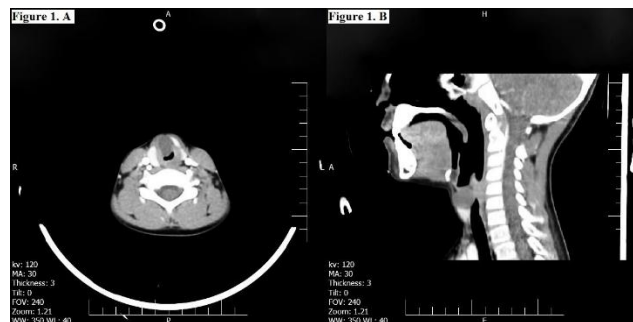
Computed tomography showing a hypodense mass in the anterior subglottic area of larynx, with a diameter of 15mm. The lesion can be seen in (A) Axial view and (B) Sagittal view
